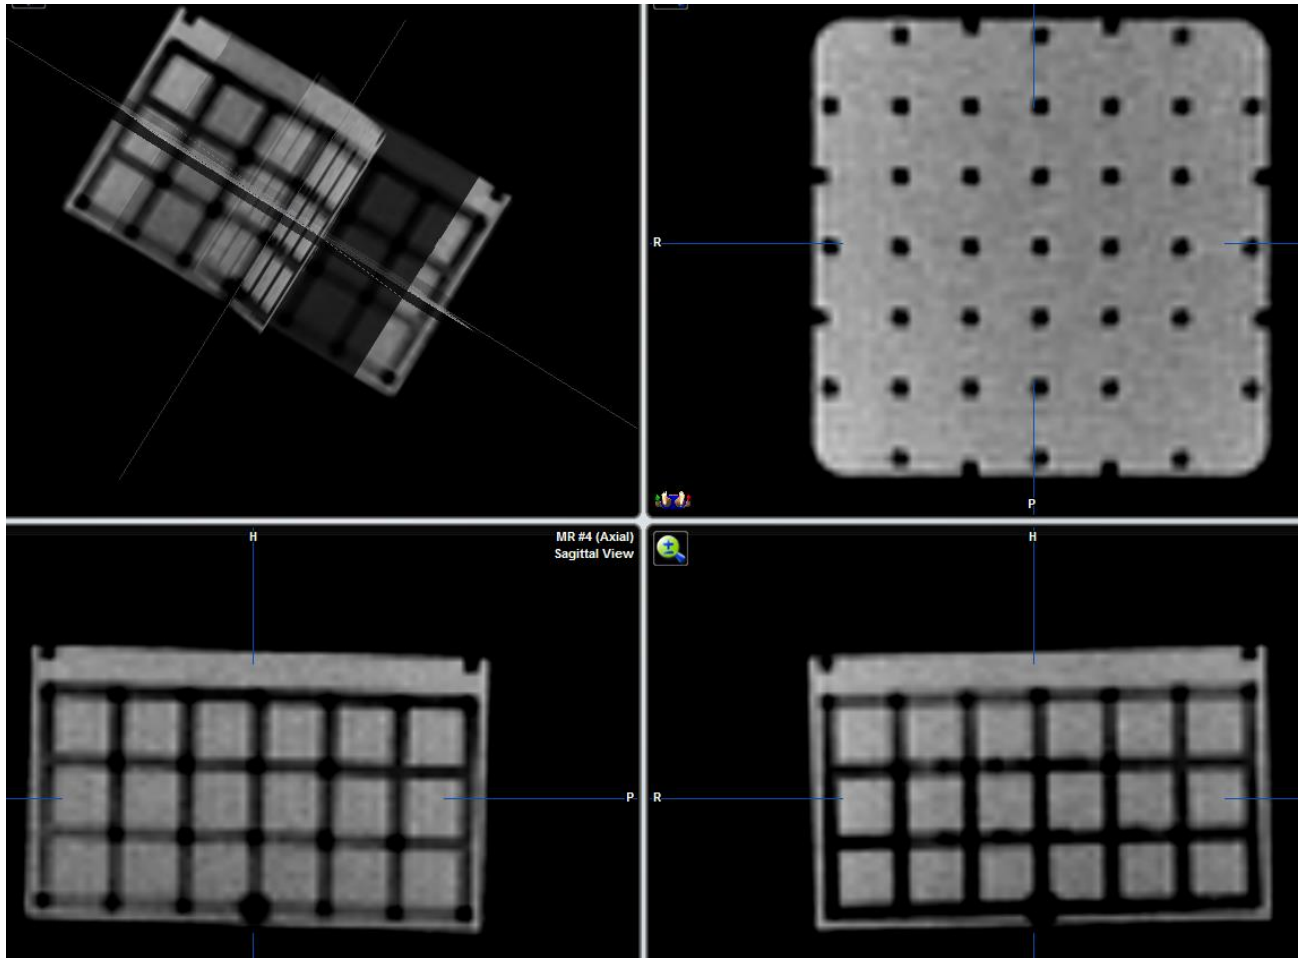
MRI scan (Axial T1, 1mm spacing) of distortion grid. Shown are clockwise from top left: 3D, axial, coronal and sagittal views.
